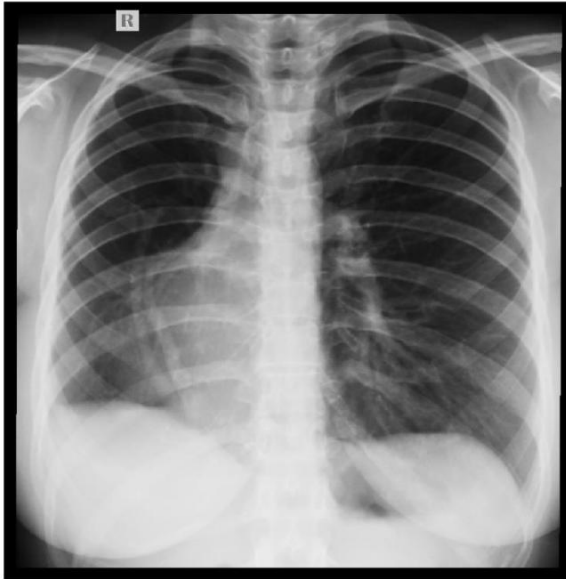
The chest radiograph revealing the Scimitar vein, a shift of the mediastinum towards the right hemithorax and a reduced volume of the right hemithorax.
